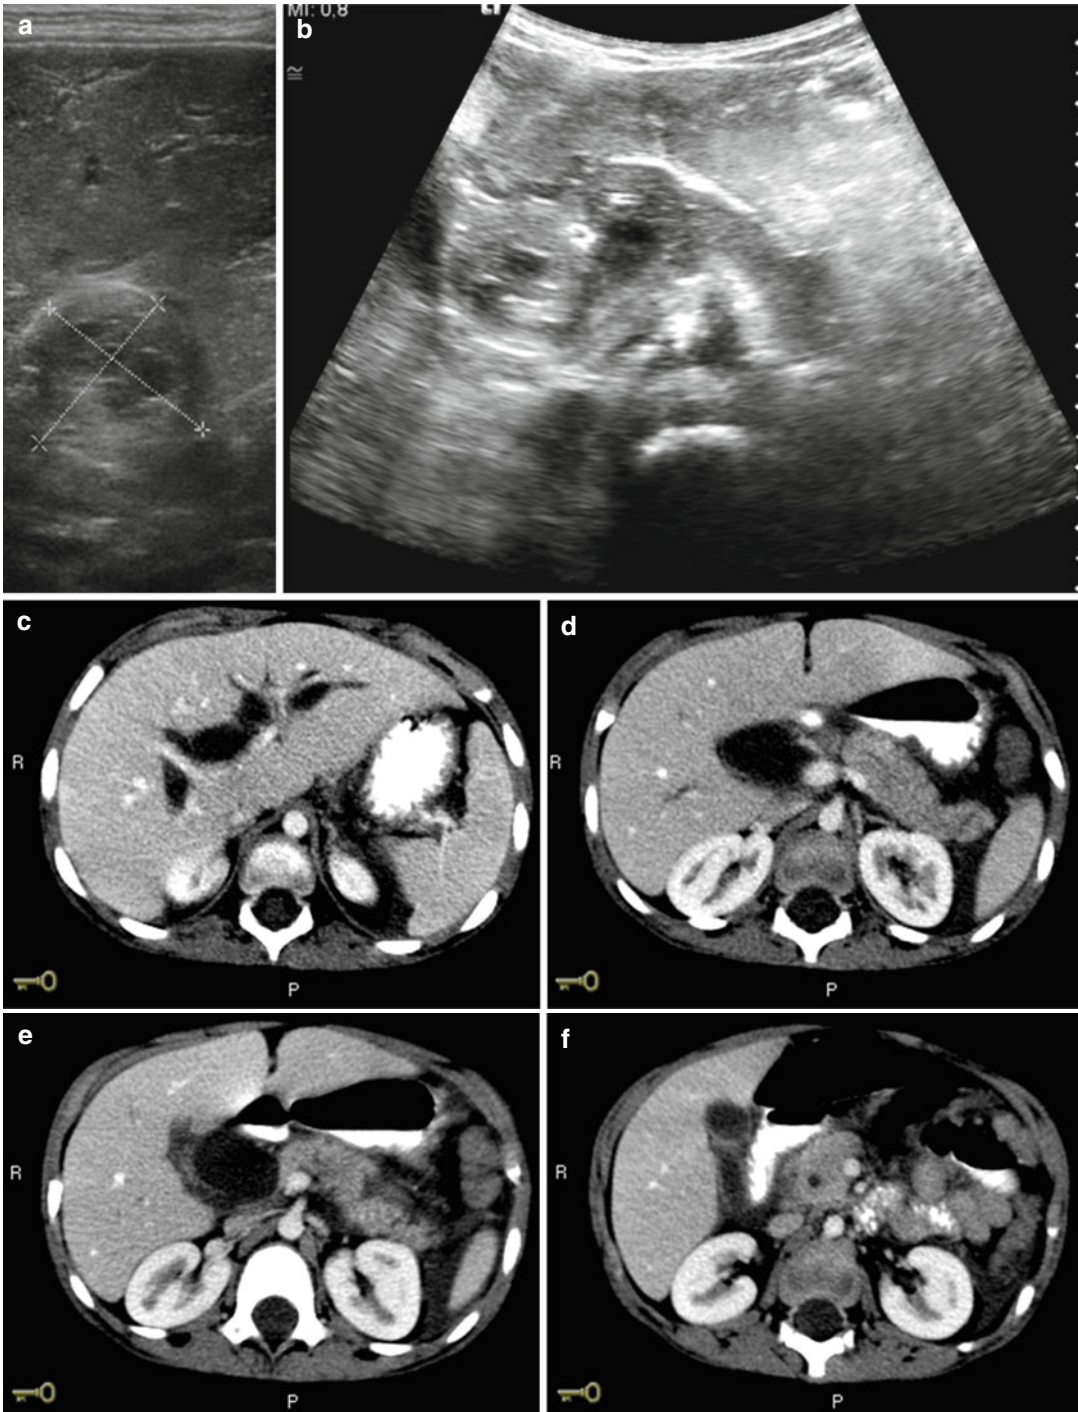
Biliary rhabdomyosarcoma. US scans (a, b) show a rounded heterogeneous cystic lesion at the liver hilum arising from the common bile duct. CT scans of the abdomen (c–f) show a noncalcified heterogeneously
